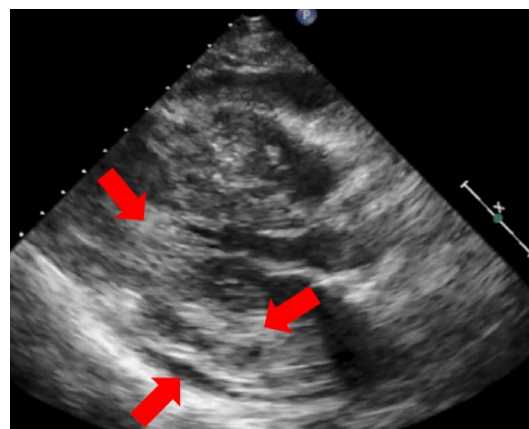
Parasternal long axis view by transthoracic echocardiography showing abnormal myocardial masses with narrowing of the endocardial cavity and pericardial effusion (arrows).
